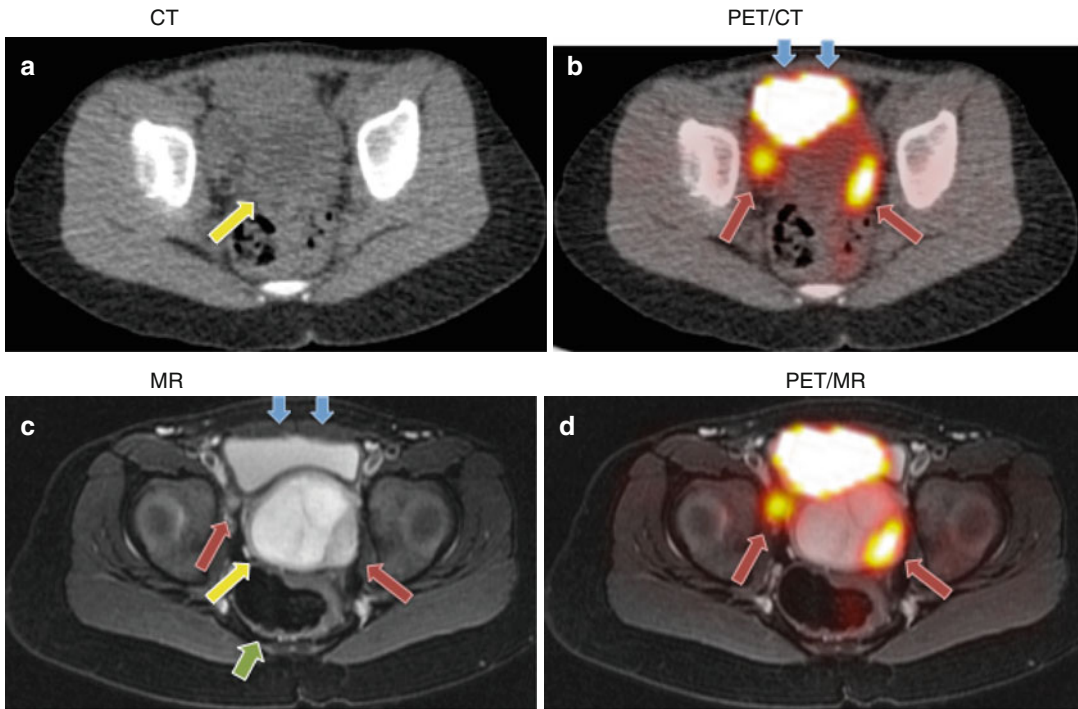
Axial ^{18}F -FDG PET/CT and sequential ^{18}F -FDG PET/MR scans through the pelvis of a patient with a rhabdomyosarcoma: (a) The unenhanced CT scan shows a mass in the pelvis (*yellow arrow*). (b) Overlay of an ^{18}F -FDG PET scan improves delineation of the urinary bladder (*blue arrows*) and two hypermetabolic tumor nodules (*red arrows*). (c) T2-w MR scan provides further improved anatomical information, delineating a T2-hyperintense
